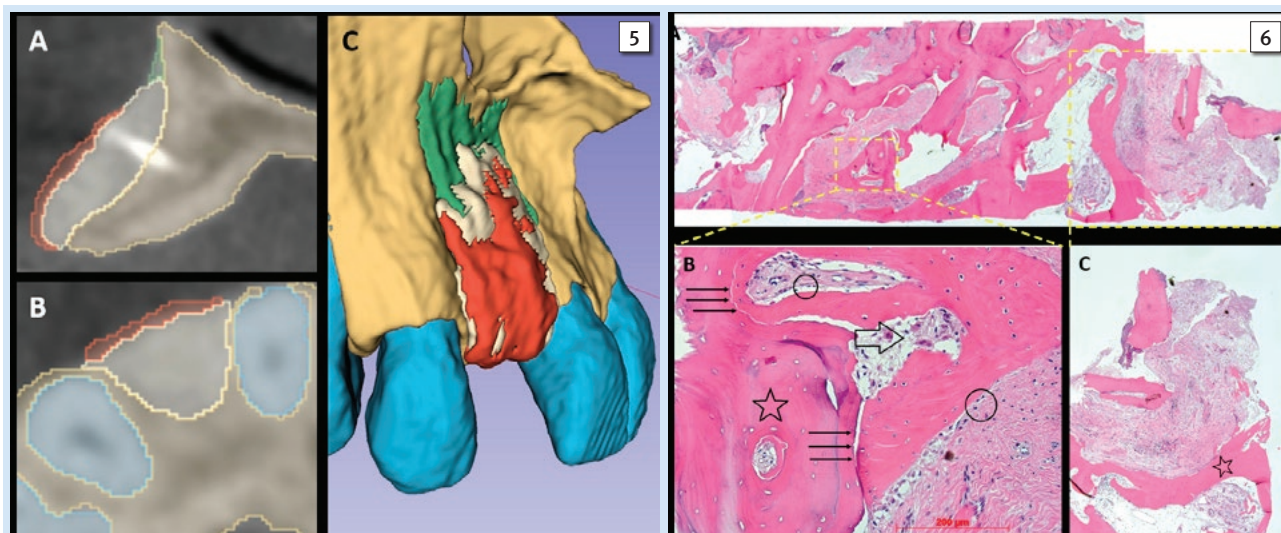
Resorption analysis with Slicer: Axial two-dimensional superimposition of all three CBCT scans, #1 (yellow line), #2 (red line) and #3 (beige line) (A). Sagittal two-dimensional superimposition of all three CBCT scans: #1 (yellow line), #2 (red line) and #3 (beige line) (B). Three-dimensional superimposition of the blocks from CBCT scan #2 (red) and #3 (green) (C).
